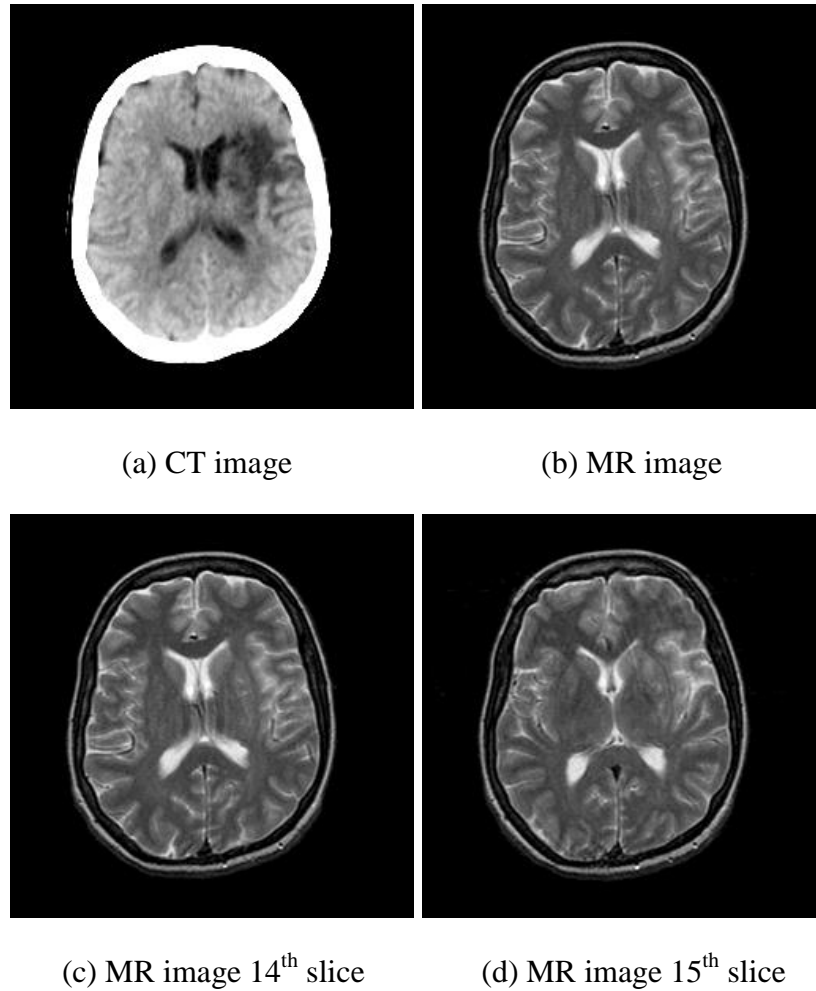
2D image slices used in our experiments. The top row is the dataset A: CT/MR image pair; the bottom row shows the dataset B: MR/MR image pair.
